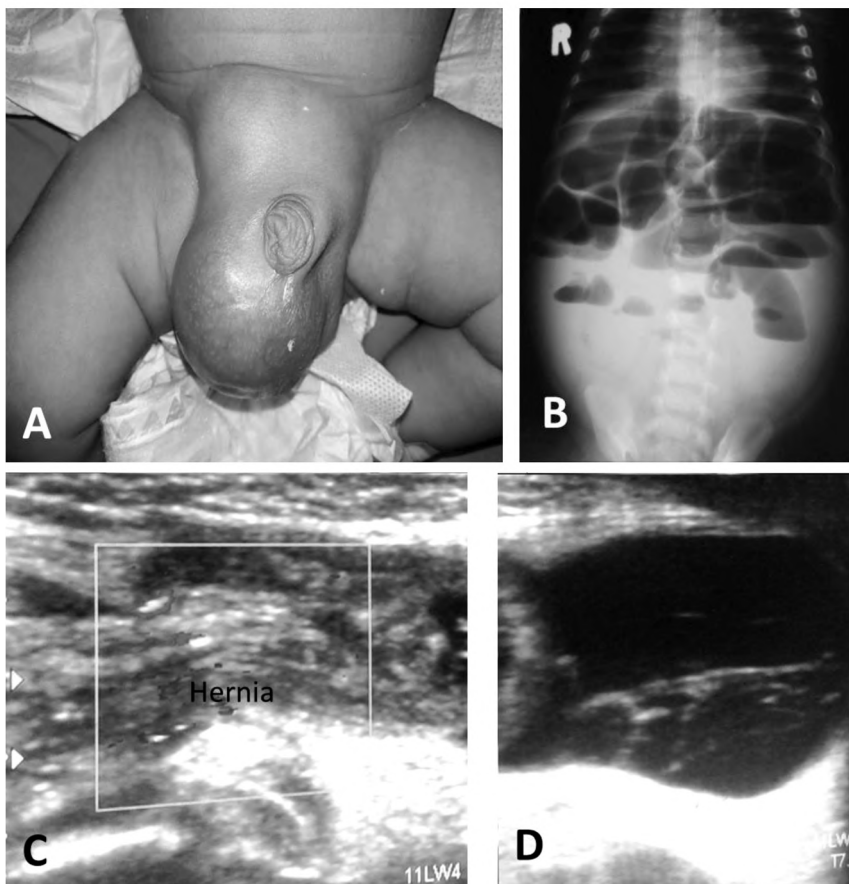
Complicated right inguinal hernia in neonate. (A) Clinical photo shows right inguino-scrotal swelling. (B) Plain X-ray abdomen shows signs of intestinal obstruction. (C) Color Doppler image demonstrating vascularity of hernial contents. (D) Sonography image shows septated hydrocele.
